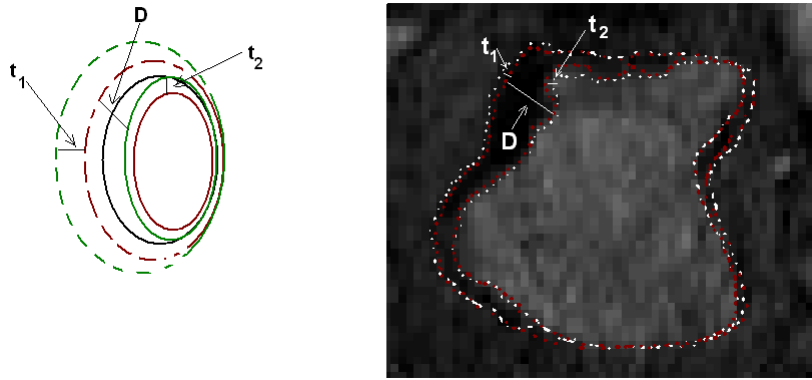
Synthetic and MRI regions with inner and outer boundaries outlined by two experts. Inner boundaries in solid, outer in dashed line; the same colour indicates results obtained from the same observer.  $t_1$  is the maximum distance between all outer boundaries,  $t_2$  that between all inner boundaries, and  $D$  the maximal separation between closest inner and outer boundaries.
